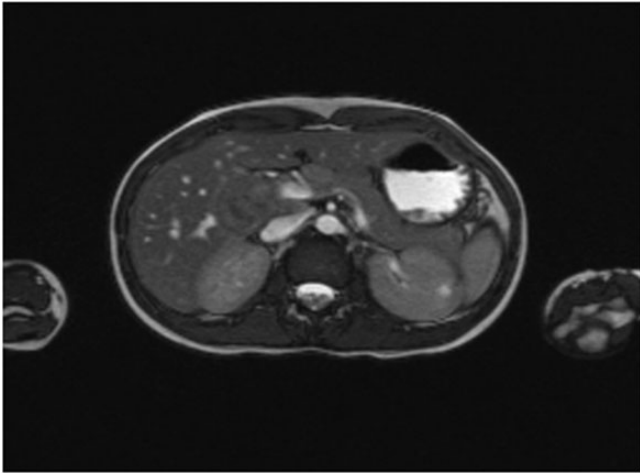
MRI abdomen shows a large irregular solid heterogeneous mass near the hilum of liver (Case 1).
